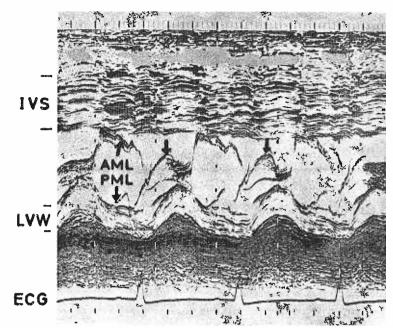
Echocardiogram of patient with hypertrophic cardiomyopathy. Unlabelled vertical arrows indicate systolic anterior motion of the mitral valve. IVS = Interventricular septum. LVW = Posterior wall of the left ventricle. (See text).
